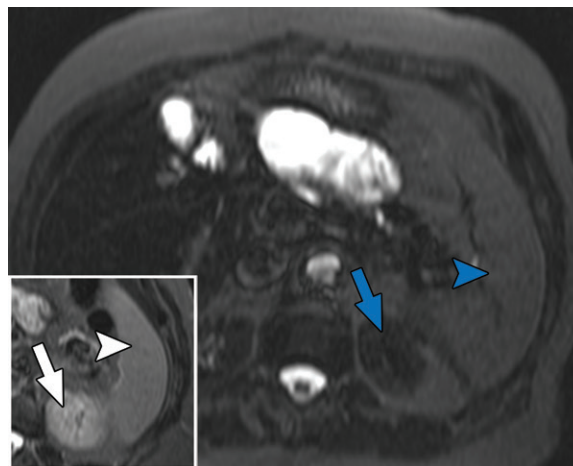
Pre- and postcontrast STIR sequences at abdominal MRI in a 76-year-old woman. STIR relies on T1 and an appropriately selected inversion time to reduce fat signal intensity. If a postcontrast STIR sequence is performed, as demonstrated on the axial MR image, the spleen (blue arrowhead) and kidney (blue arrow) will have reduced signal intensity owing to the T1-shortening effects of gadolinium compared with their normal signal intensity on the axial precontrast STIR image (inset). STIR sequences should be performed only before contrast agent administration.
